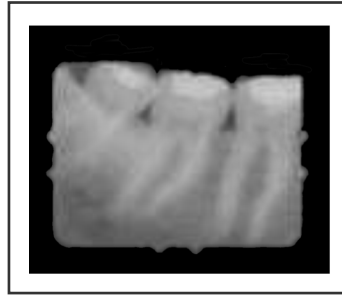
Periapical radiograph¹¹
